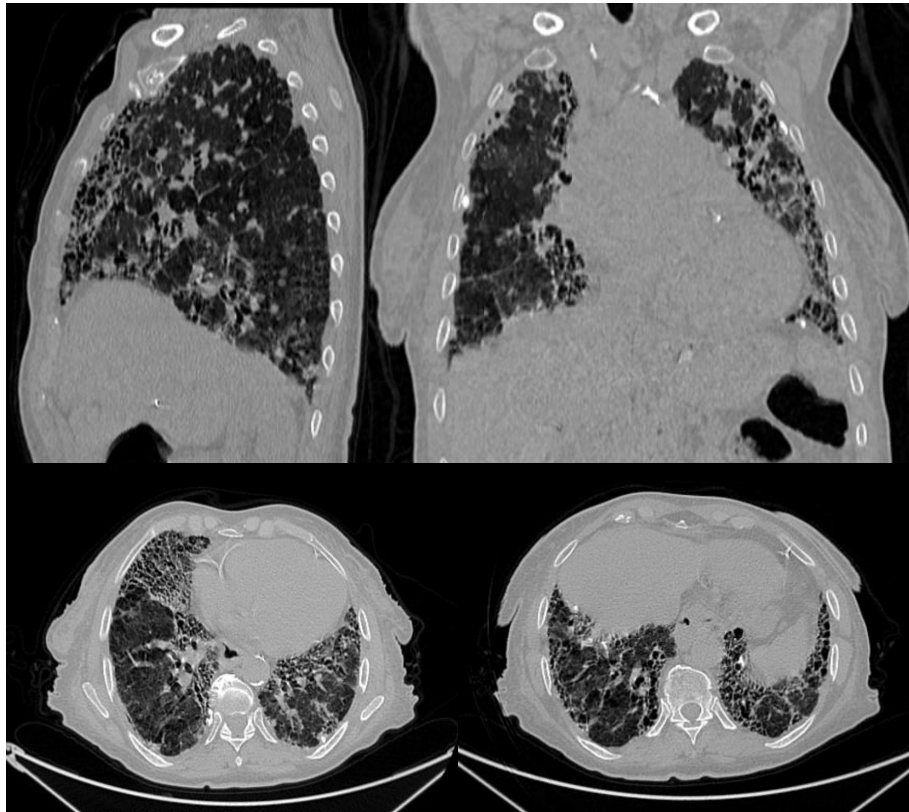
69-year-old female patient presenting with dyspnea for several weeks. Chest CT scan without contrast, axial, coronal, and sagittal slices; parenchymal window: Diffuse bilateral subpleural septal and non-septal thickening creating a honeycomb pattern. Cylindrical bronchiectasis foci with peribronchovascular thickening. Bilateral ground-glass opacities without a specific distribution.
